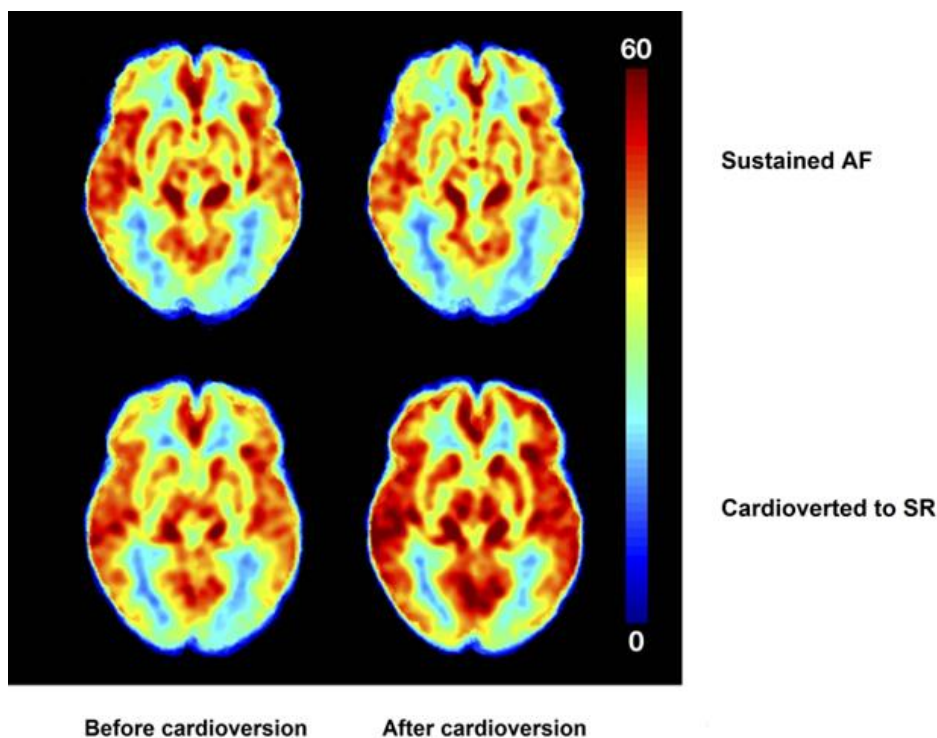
Average brain perfusion map of the whole brain before and after cardioversion measured by ASL MRI in Paper II.
